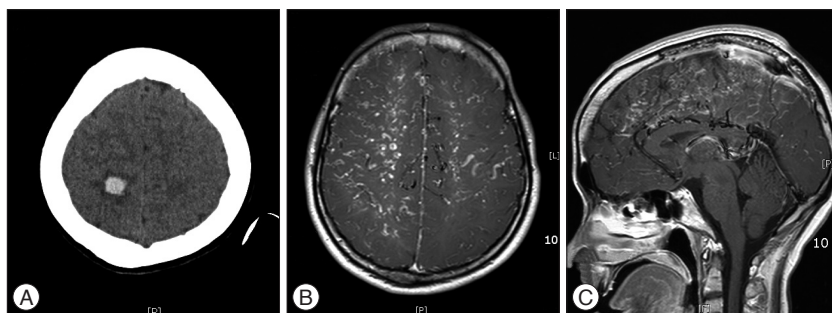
A : Computed tomography axial image demonstrate a small intracerebral hemorrhage in the right parietal cortex. B and C : Magnetic resonance imaging demonstrate thrombosis at the posterior segment of superior sagittal sinus and dural arteriovenous fistula with a prominent and tortuous venous enhancement along the centrum semiovale.
